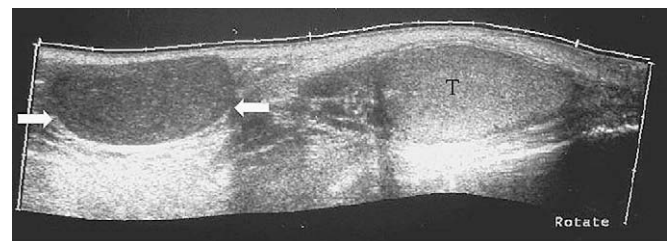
Patient with a palpable mass in the inguinal region. Longitudinal EFOV sonogram showing a hypoechoic solid lesion (arrows) at the superolateral aspect of the right testis (T). The pathologic diagnosis confirmed lipoma.
